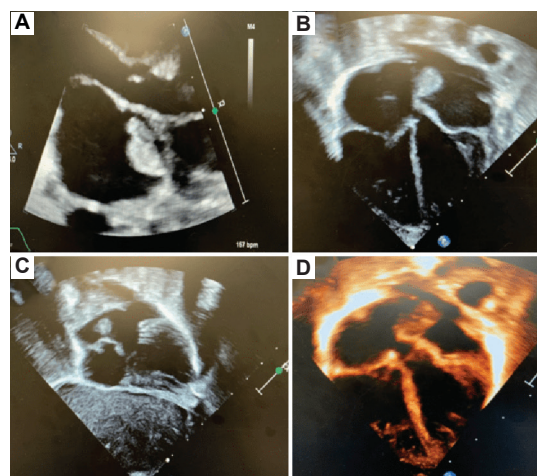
Echocardiogram on days of life 6 shows moderate-to-large sized thrombus/vegetation with several lobes measuring 6 × 9 mm. (A) Parasternal long axis view; (B) apical four-chamber view; (C) five-chamber view; and (D) subcostal view.
